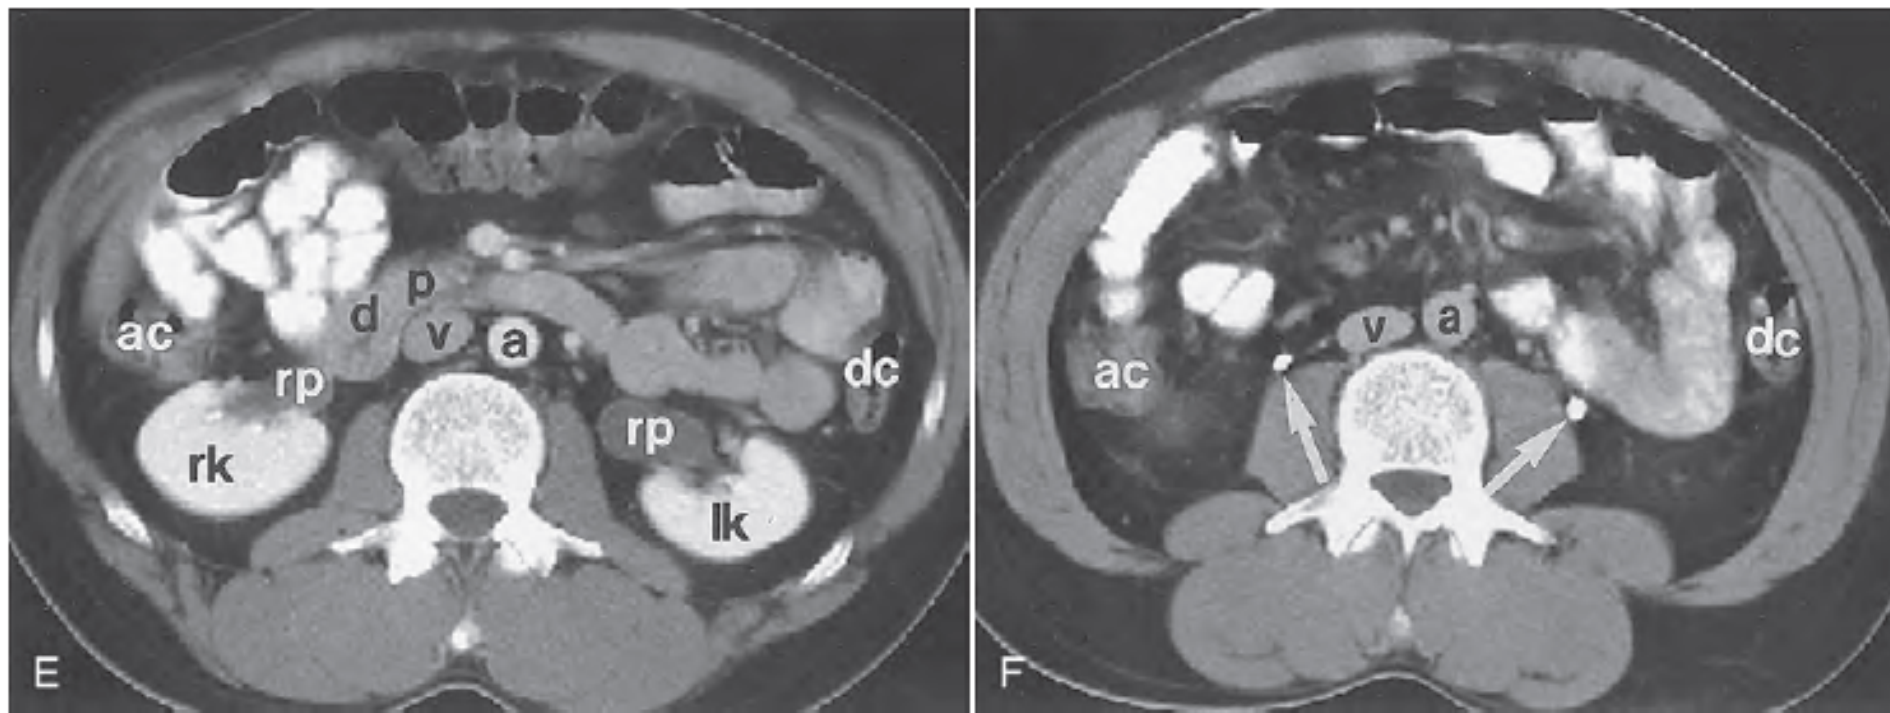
Computed tomography of the abdomen and pelvis demonstrating normal genitourinary anatomy. A, The adrenal glands are indicated with *arrows*. The upper poles of the right and left kidneys are indicated with *rk* and *lk*, respectively. *a*, aorta; *li*, liver; *p*, pancreas; *s*, spleen; *v*, inferior vena cava. B, Scan through the upper pole of the kidneys. The left adrenal gland is indicated with an *arrow*. *a*, aorta; *c*, colon; *d*, duodenum; *li*, liver; *lk*, left kidney; *p*, pancreas; *rk*, right kidney; *v*, inferior vena cava. C, Scan through the hilum of the kidneys. The main renal veins are indicated with *solid arrows*, and the right main renal artery is indicated with an *open arrow*. *a*, aorta; *c*, colon; *d*, duodenum; *li*, liver; *lk*, left kidney; *p*, pancreas; *rk*, right kidney; *v*, inferior vena cava. D, Scan through the hilum of the kidneys slightly caudal to C. The left main renal vein is indicated with a *solid straight arrow*, and the left main renal artery is indicated with an *open arrow*. The hepatic flexure of the colon is indicated with a *curved arrow*. *a*, aorta; *c*, colon; *d*, duodenum; *li*, liver; *lk*, left kidney; *p*, pancreas; *rk*, right kidney; *v*, inferior vena cava. E, Scan through the mid to lower polar region of the kidneys. *a*, aorta; *ac*, ascending colon; *d*, duodenum; *dc*, descending colon; *lk*, left kidney; *p*, pancreas; *rk*, right kidney; *rp*, renal pelvis; *v*, inferior vena cava. F, CT scan obtained below the kidneys reveals filling of the upper ureters (*arrows*). The wall of the normal ureter is usually paper thin or not visible on CT. *a*, aorta; *ac*, ascending colon; *dc*, descending colon; *v*, inferior vena cava.
